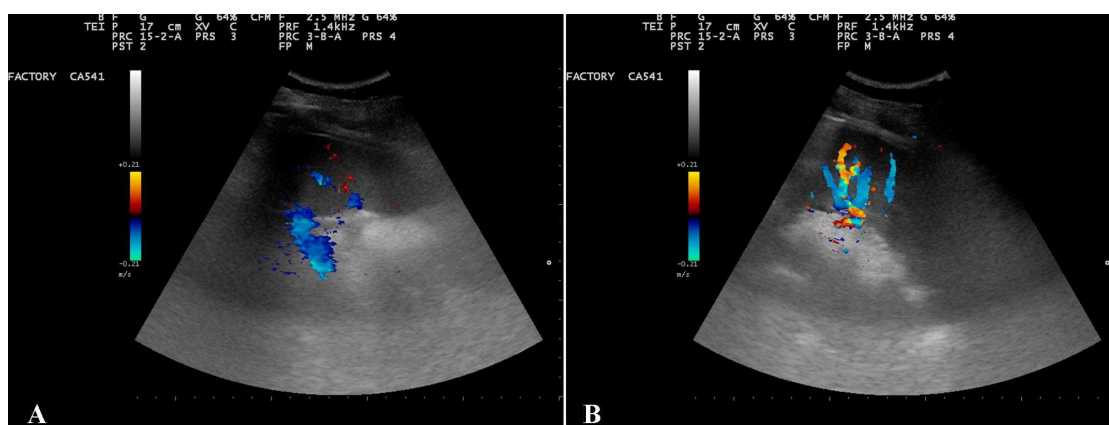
Increased splenic blood flow following administration of OA-GcMAF. Oleic Acid (OA) complexed with vitamin D binding protein-derived Macrophage Activating Factor (OA-GcMAF, Goleic; Immuno Biotech Ltd, Guernsey, Channel Islands), 880 ng, dissolved in 5 mL saline, was administered by nebulisation. Splenic blood flow was assessed by echo-colour-doppler ultrasonographic technique. Panel A, basal, i.e., before any administration of OA-GcMAF. Panel B, 48 h after OA-GcMAF administration. The increase in peripheral splenic blood flow is evident. This picture is representative of several others that gave qualitatively identical results
